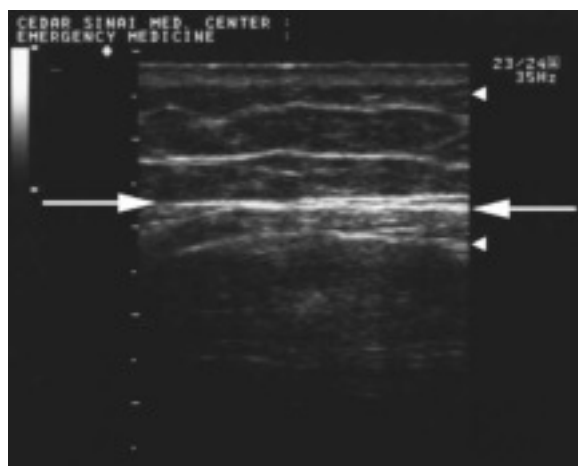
Sonographic appearance of a normal lung using a linear array 7.5-Mhz probe. The hyperechoic line represents the pleura (arrows). Absence of the lung-sliding sign (seen in real time) indicates a pneumothorax.
